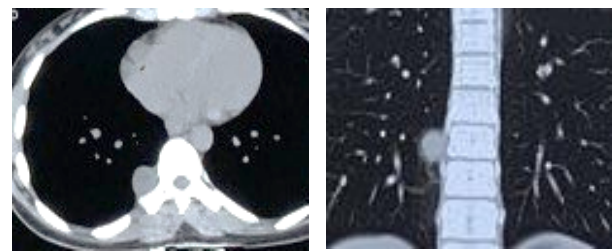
Contrast enhanced high resolution CT scan of the chest showing a homogenous soft tissue mass in the right paravertebral space at the level of 10th intercostal space without calcification, moderate contrast enhancement with no extension is seen into the spinal canal [A, B].
